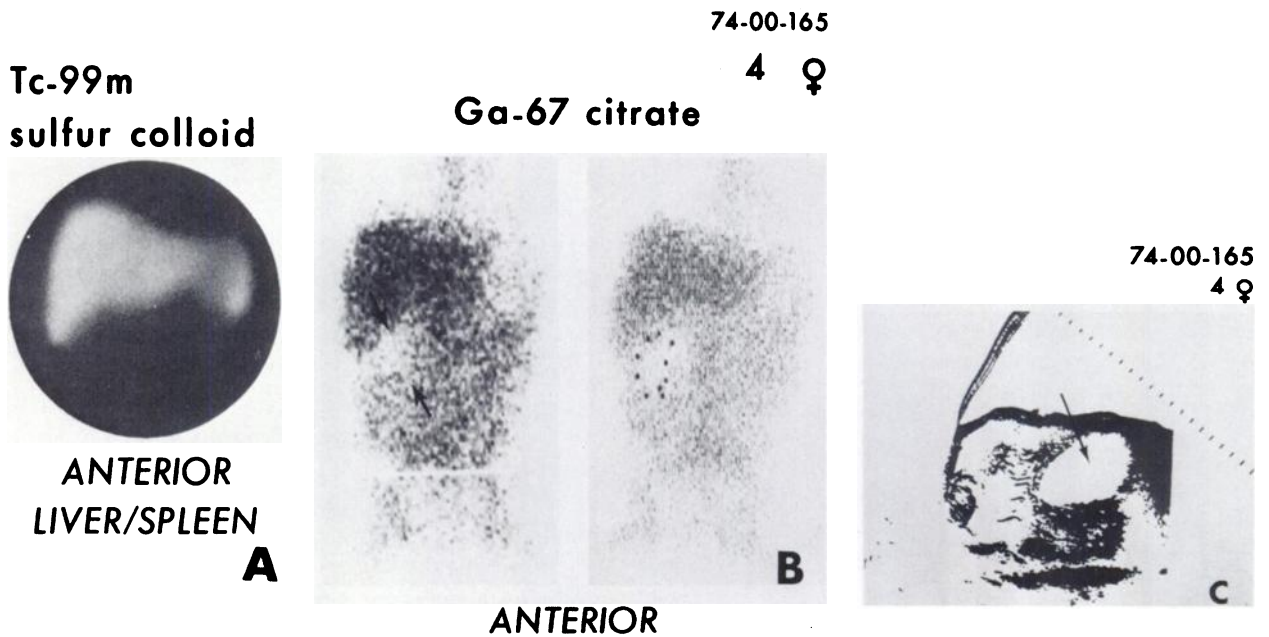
Four-year-old girl with fever, leukocytosis (predominantly lymphocytic). She developed an ill-defined right upper quadrant mass on day of Ga-67 scan. (A) Normal Tc-99m sulfur colloid liver scan. (B) Gallium-67 scan demonstrated "cold" defect in area of gallbladder. Before repeat scan, markers were placed in area of palpable mass and correspond to "cold" or photopenic area. (C) Sonogram demonstrates echo-free mass in area of gallbladder (arrow). Surgical diagnosis was sterile hydrops of gallbladder due to obstruction by enlarged periportal nodes.
